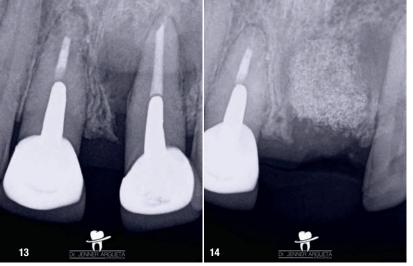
Initial radiograph of teeth #11 and 21. Radiolucent areas in both teeth were visible, and cemental tears were present in tooth #21. Fig. 14: Bone grafting material placed at the extraction site of tooth #21.
